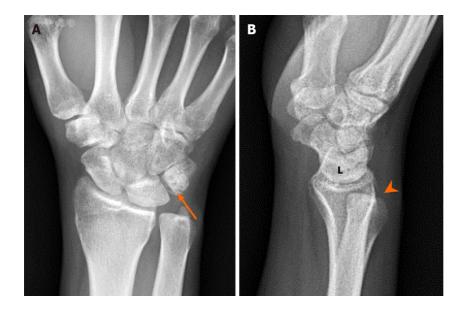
Five months postoperative plain radiograph showed appropriate lunate alignment. A: The radiograph showed solid union of the avulsed triquetrum (arrow) with no associated widening of the scapholunate and lunotriquetral joint space, and no necrotic changes in the lunate; B: Lateral view of the wrist joint showed a neutral scapholunate ligament with no obvious volar or dorsal intercalated segment instability. However, residual distal radioulnar joint subluxation was observed during follow-up (arrowhead).
